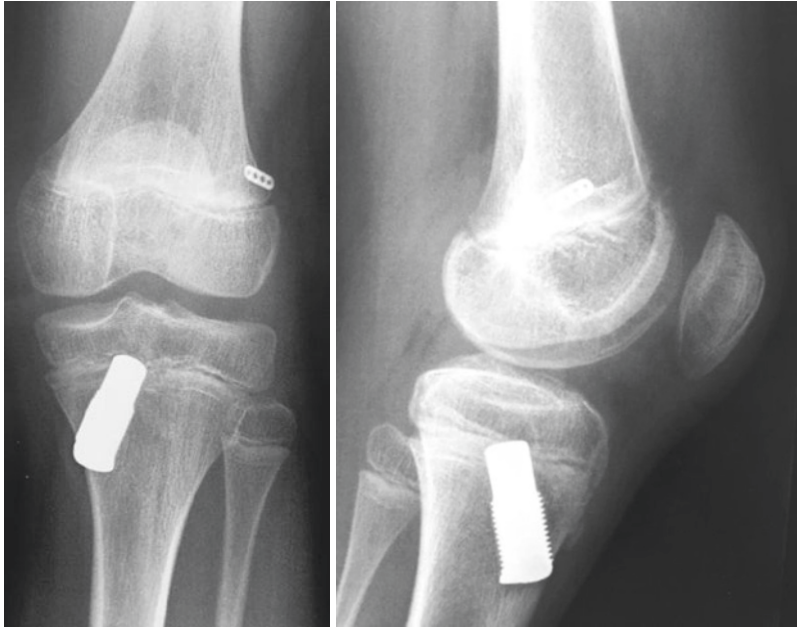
Radiographs of a 12-year-old boy operated with an ACL repair technique. The boy developed a functional instability after surgery caused by insufficiency of the repair. The 10 mm metal monobloc containing a suture-tensioning device crossed the proximal tibial growth
